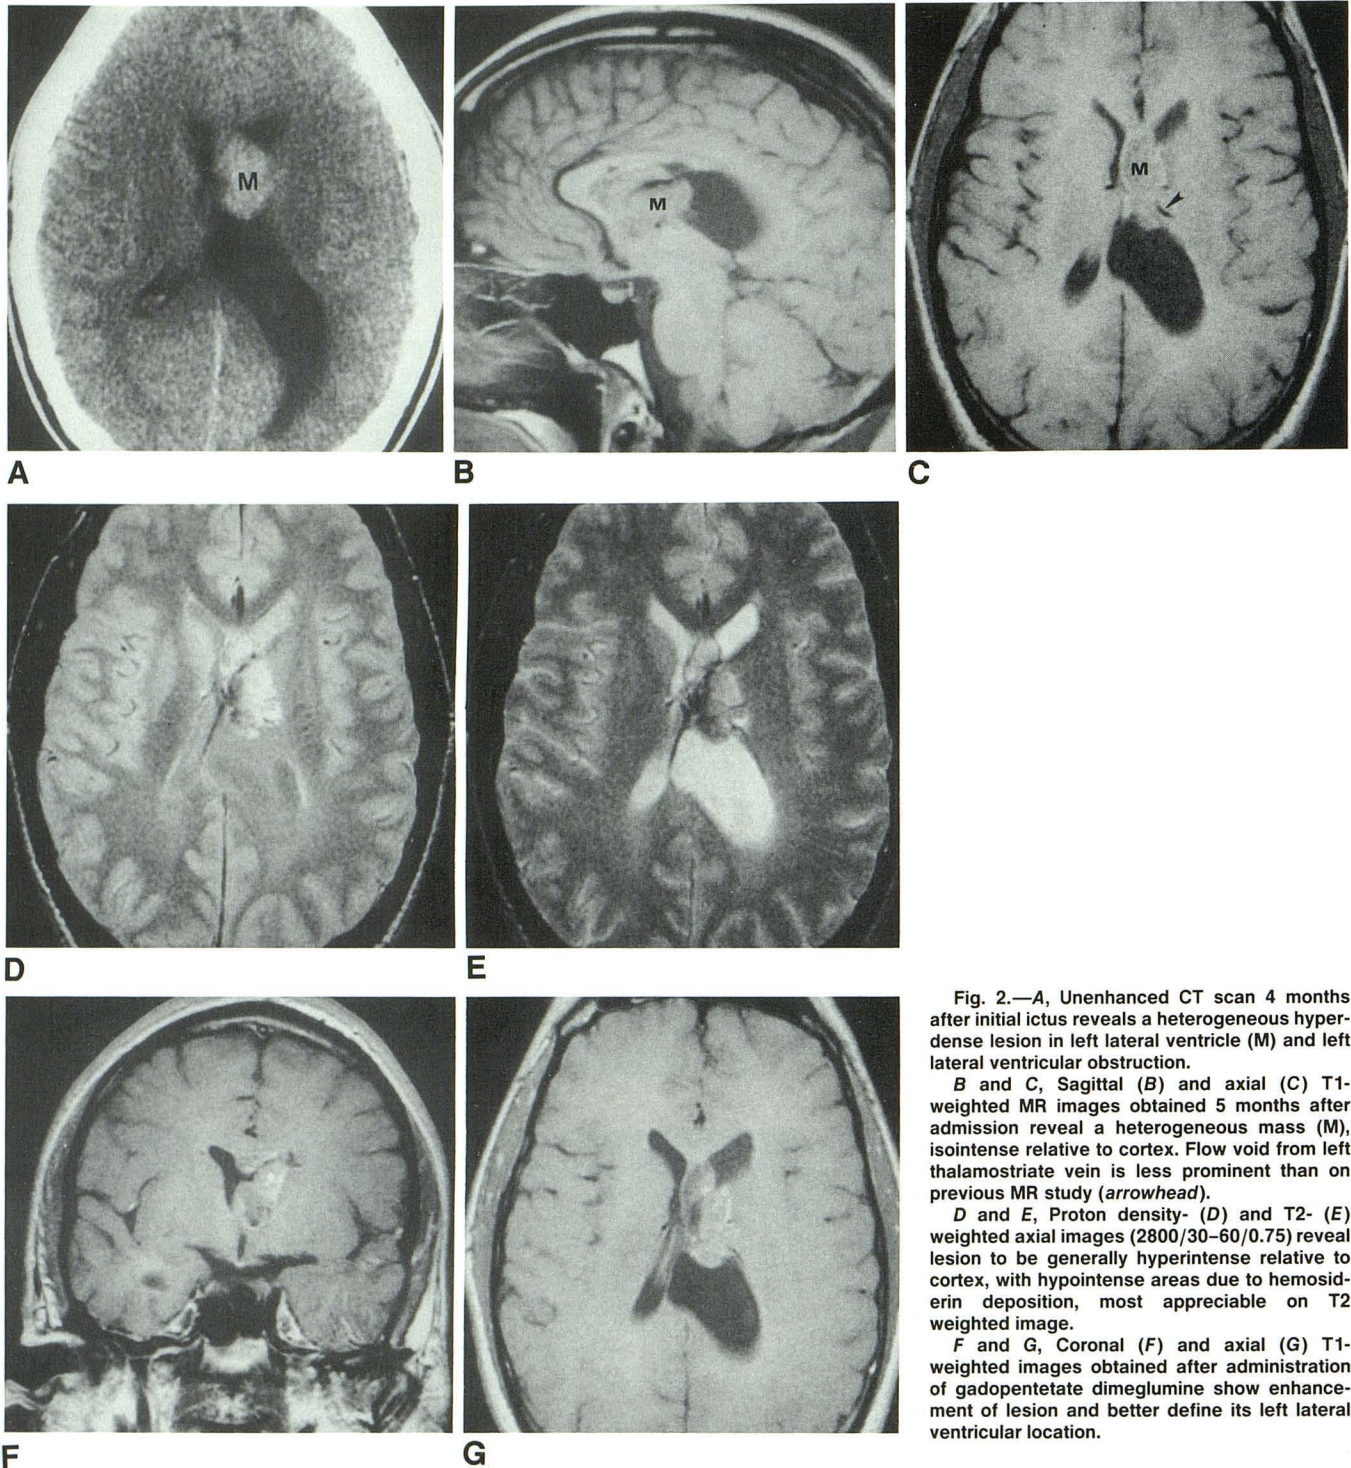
A, Unenhanced CT scan 4 months after initial ictus reveals a heterogeneous hyperdense lesion in left lateral ventricle (M) and left lateral ventricular obstruction.
